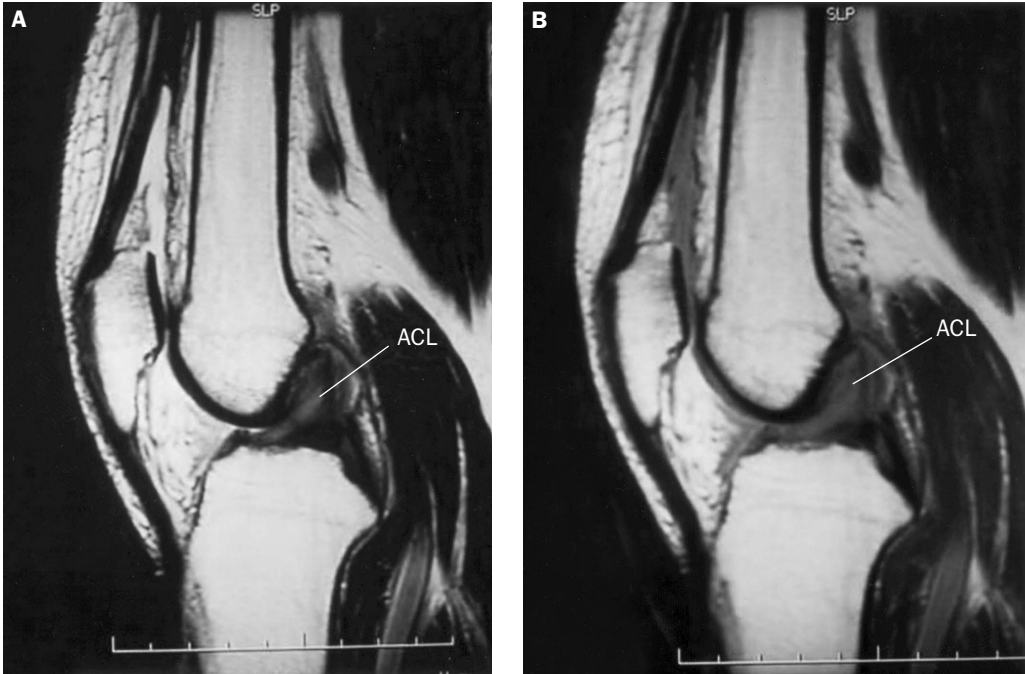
Case 1: (A) sagittal T2-weighted image and (B) proton density show increasing intraligamentous signal intensity of the anterior cruciate ligament (ACL) over the left knee.
